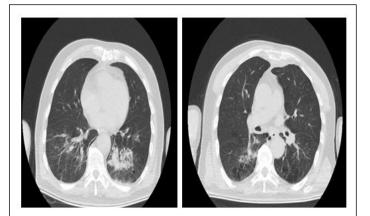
Computed tomography of chest axial view. Ground-glass opacities, paving pattern and patchy consolidations.
